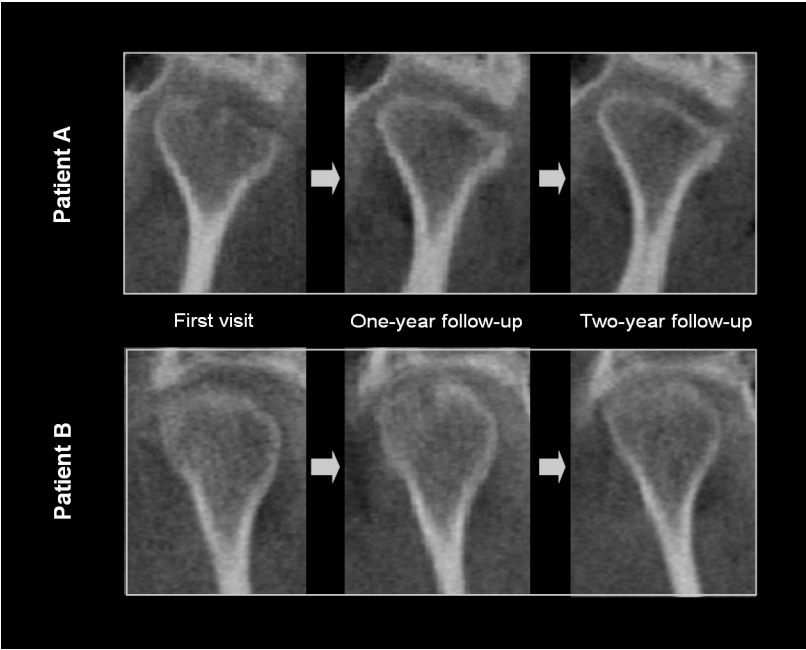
Frontal views of cone-beam computerized tomographs, showing the two-year development of a temporomandibular joint in two patients with TMJ erosions. Patient A showed TMJ erosion at first visit and received intra articular injection of glucocorticoids. At the one-year follow-up the erosion was absent and the new bone stayed in remission at the two-year follow-up. Patient B developed TMJ erosion during the first year after diagnosis which was treated with intra articular glucocorticoid injection at the one-year follow-up. New bone formation was observed at the two-year follow-up.
